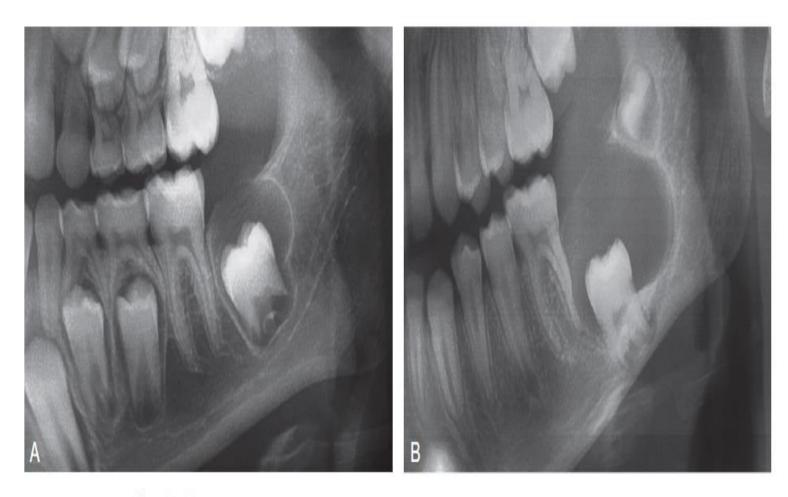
Ameloblastoma. A, Unilocular radiolucency surrounding the crown of the developing left mandibular second molar, which mimics a small dentigerous cyst. B, This radiograph from 3 years later shows enlargement of the lesion, including inferior displacement of the tooth. (Courtesy of Dr. Patrick Scioscia.)
